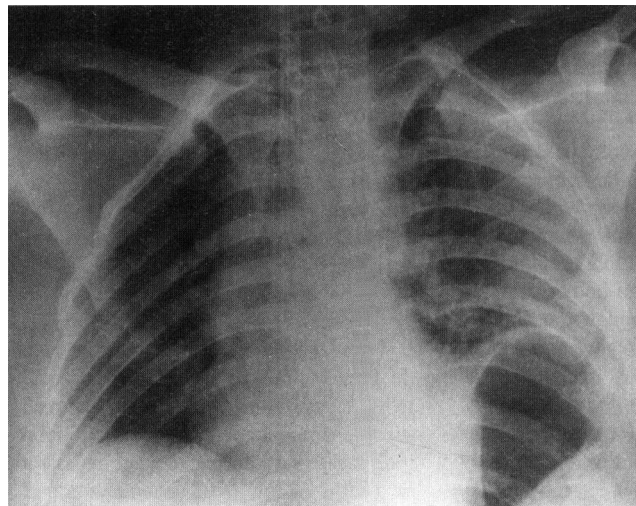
A repeated radiograph 12 weeks after a blunt injury to the abdomen within the thorax, confirming the endoscopic findings of the ruptured diaphragm
